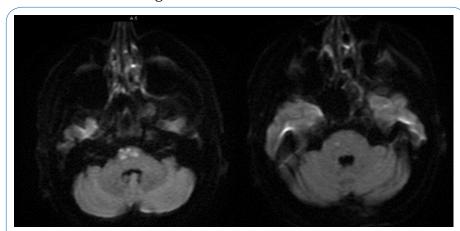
Restricted diffusion in the diffusion weighted sequence of MRI demonstrating enhancement of heterogeneous diffusion-restricting lesion in the bulbus
